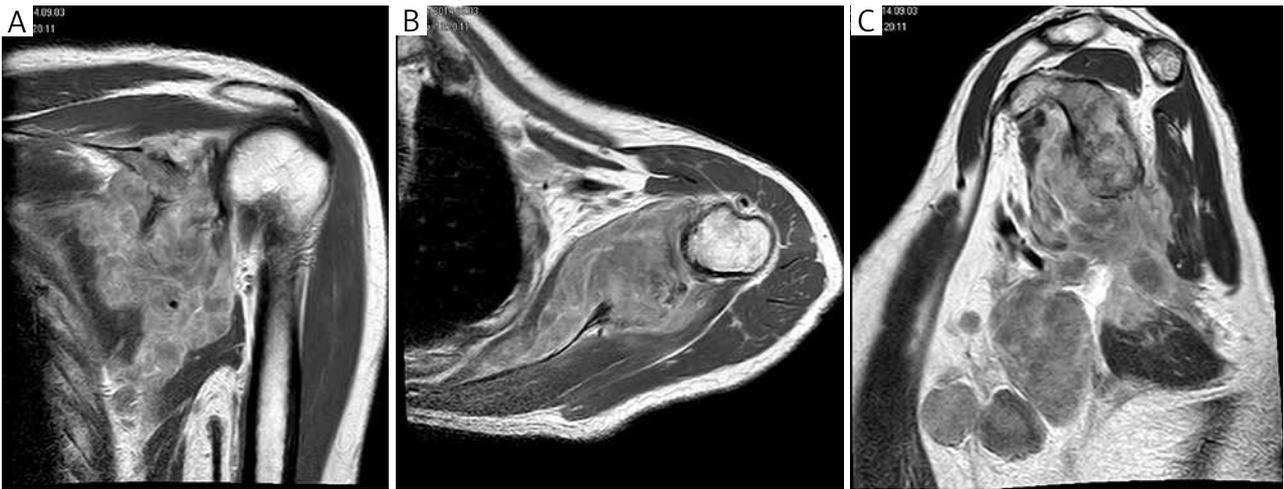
A–C) MRI of the left shoulder demonstrating the whole involvement of the scapula as well as loco-regional soft tissue metastases
